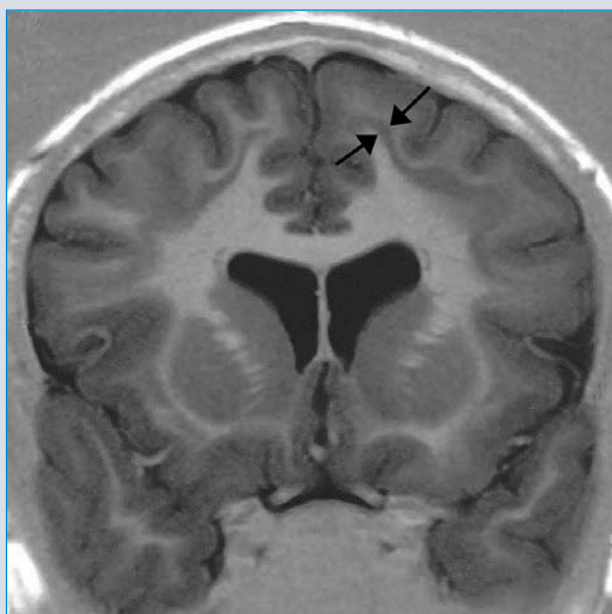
Brain MRI scan; coronal section: young woman with a missense mutation of the *DCX* gene. The gyral pattern of the cortex looks normal but beneath the cortex, and separated from it by a thin layer of white matter, is present a subcortical laminar (band) heterotopia (black arrow) showing the same signal intensity as the cortex. The thickness of the heterotopic band is variable from about 3 mm to 1 cm.
